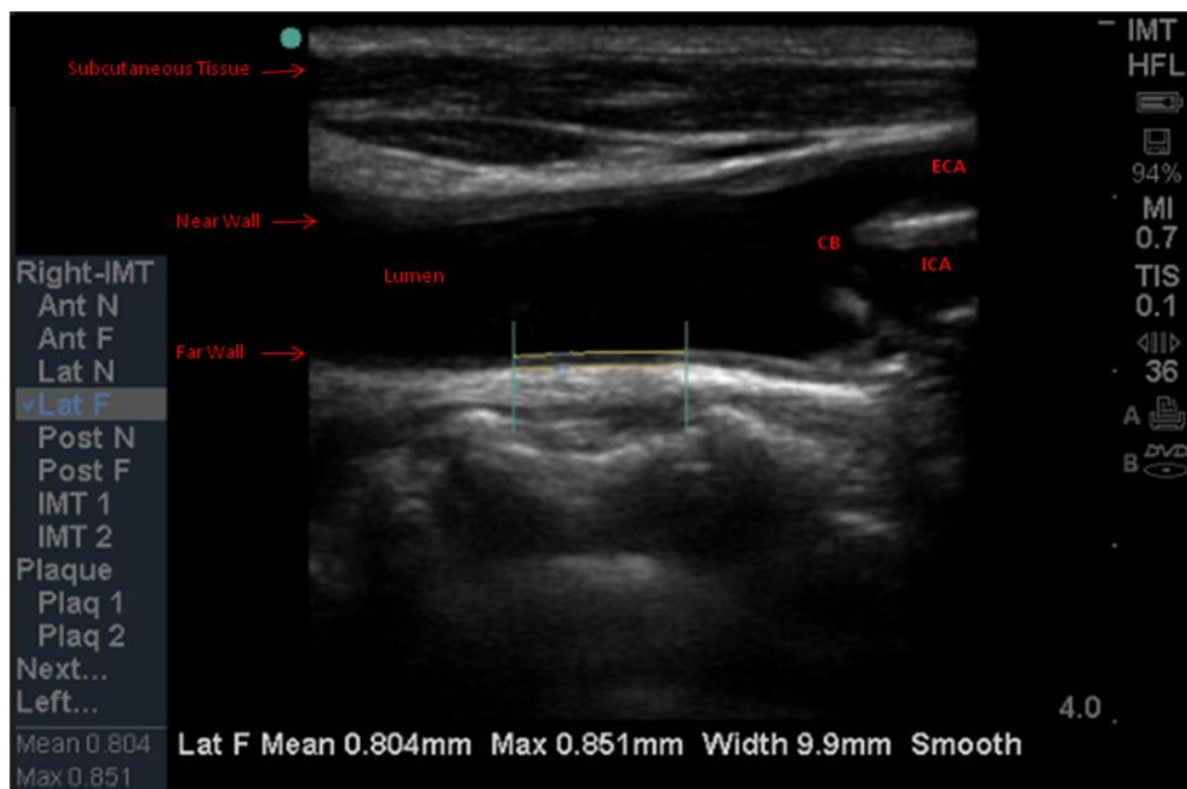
Ultrasonography of a 68 year old with critical limb ischaemia, showing the right lateral wall of the common carotid intima-media thickness (indicated by the double yellow line), 1 cm from the carotid bifurcation (CB) forming the right external (ECA) and internal (ICA) carotid arteries.
